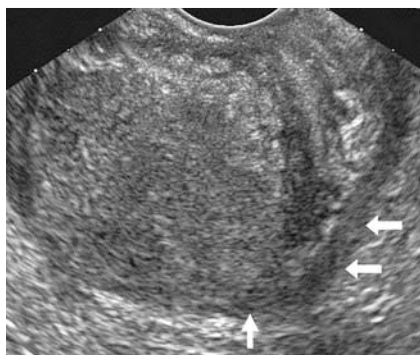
Endoscopic ultrasound (EUS) showing a submucosal lesion in the antrum. Muscularis propria is seen around the lesion (white arrows).
